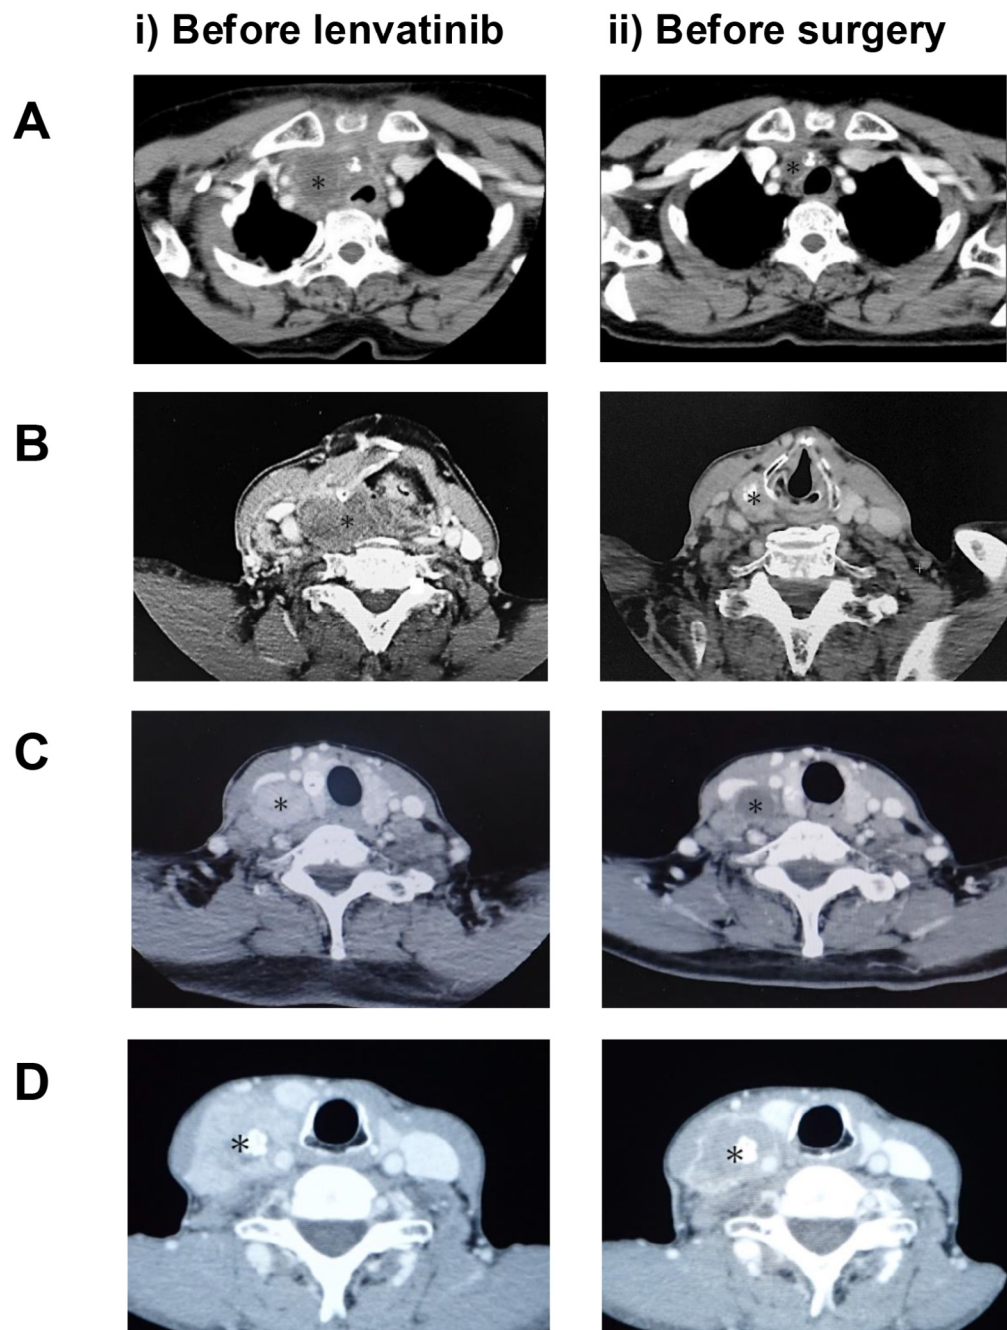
Computed tomography images before lenvatinib treatment (left) and (right) before surgery (left) for cases 1 to 4 (A-D), respectively. The asterisks indicate the target lesions. In each case, lenvatinib treatment was effective, resulting in tumor shrinkage or cystic degeneration.
